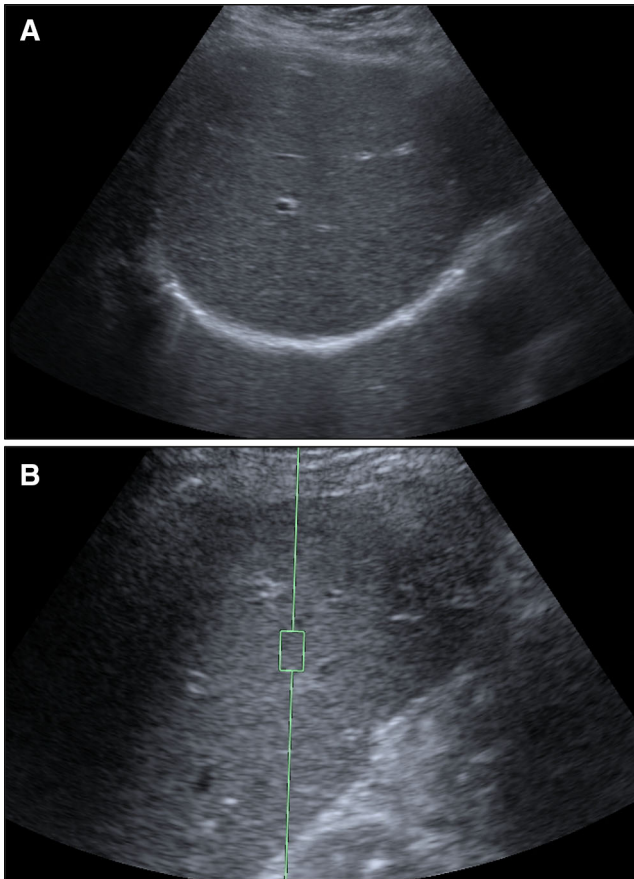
A, B Ultrasound of a 61-year-old woman with HIV and hepatitis C presenting for fibrosis screening shows potentially treatable liver fibrosis on ARFI prior to morphologic changes on grayscale ultrasound. (A) Grayscale ultrasound of the right hepatic lobe shows a normal smooth echotexture. (B) ARFI shows a shear wave velocity of 1.79 m/s (F3).
